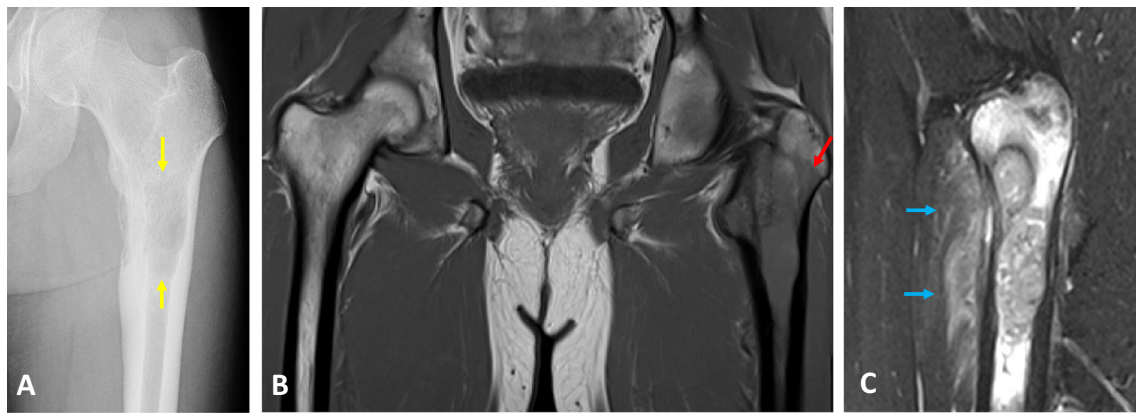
A 21-year-old male with Ewing sarcoma. Radiograph (a) demonstrates a subtle lucency (yellow arrows) of the left proximal femoral diaphysis with associated endosteal scalloping laterally and cortical thickening medially. This appearance can mimic osteomyelitis. Coronal T1-weighted STIR image of both hips (b) demonstrates diffusely decreased signal intensity of the proximal femur. Note the sharp transition
